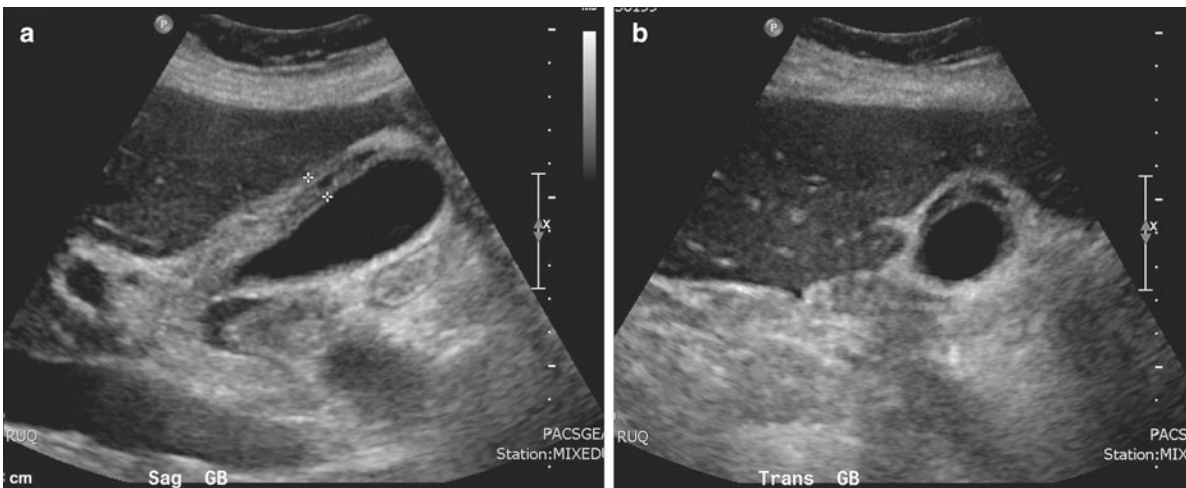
A 79-year-old man with sepsis, severe RUQ abdominal pain and tenderness. (a) Sagittal real-time ultrasound shows thick gallbladder wall (6 mm) (*asterisks*). (b) Transverse real-time ultrasound shows thick gallbladder wall (6 mm). Diagnosis: Acute cholecystitis
